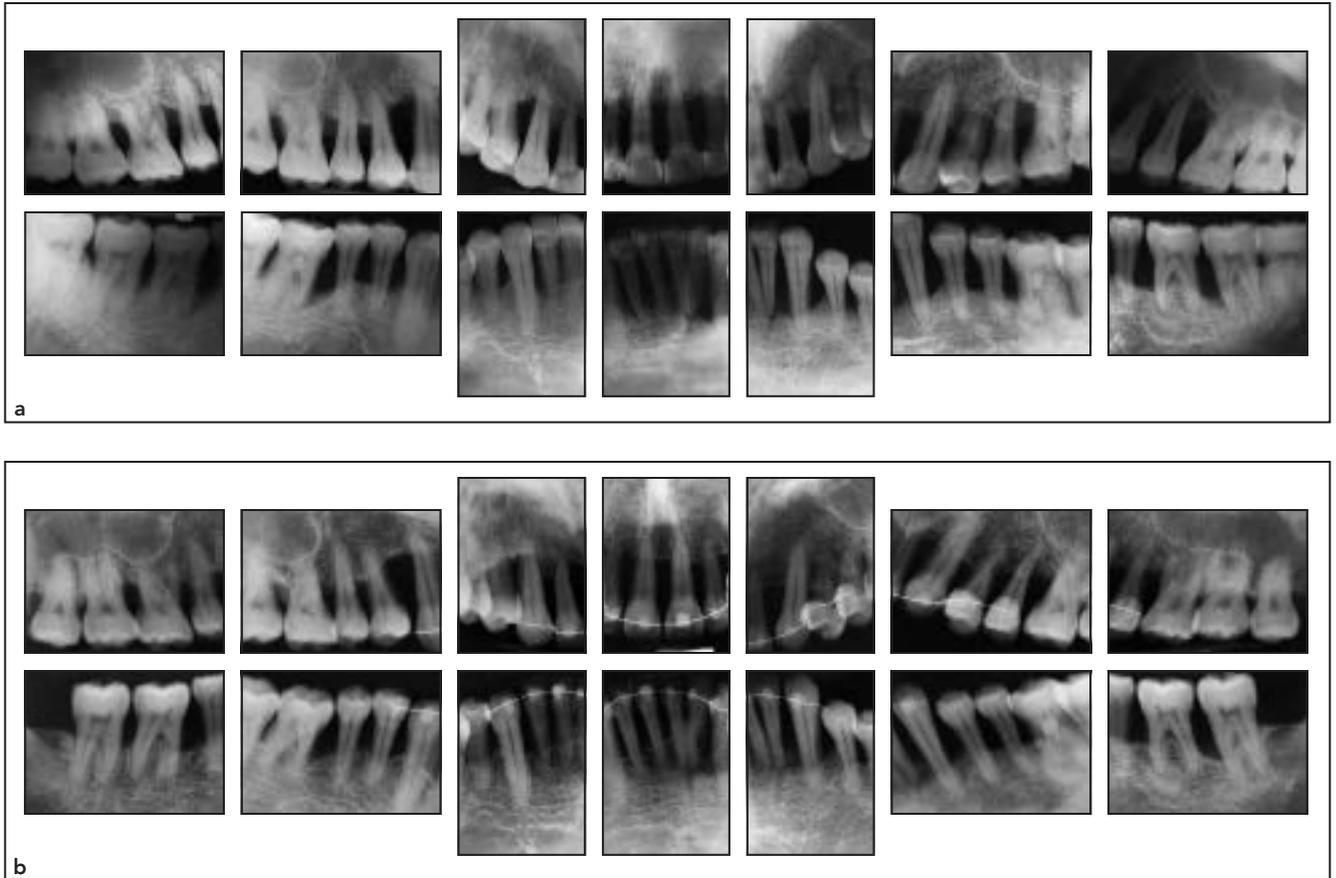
Radiographs. (a) Initial set. (b) Five years after treatment.
